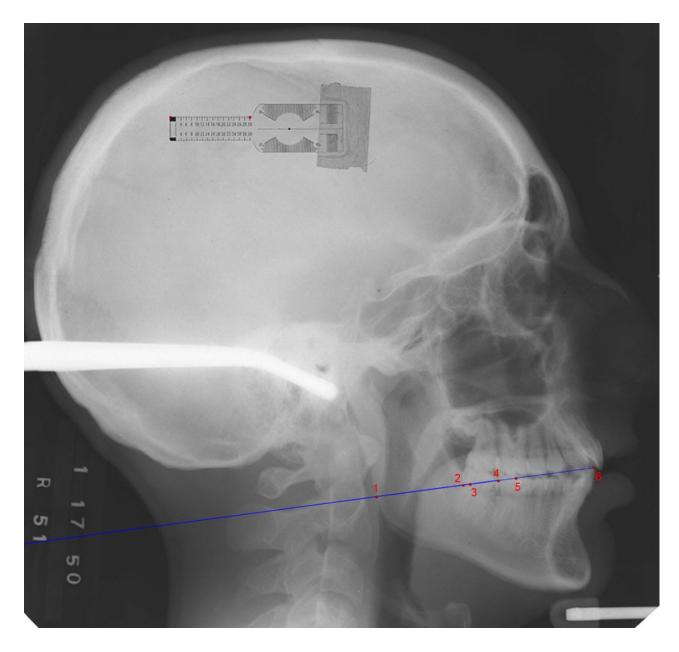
Example of a lateral cephalometric radiograph with identified digital landmarks: 1, the posterior border of the ramus; 2, the distance between the distal of the lower 2nd permanent molar to the anterior border of the ramus; 3, the anterior border of the ramus; 4, the distance between the distal of the lower 1st permanent molar to the anterior border of the ramus; 5, the occlusal of the lower 1st permanent molar; 6, the lower central incisor tip.
